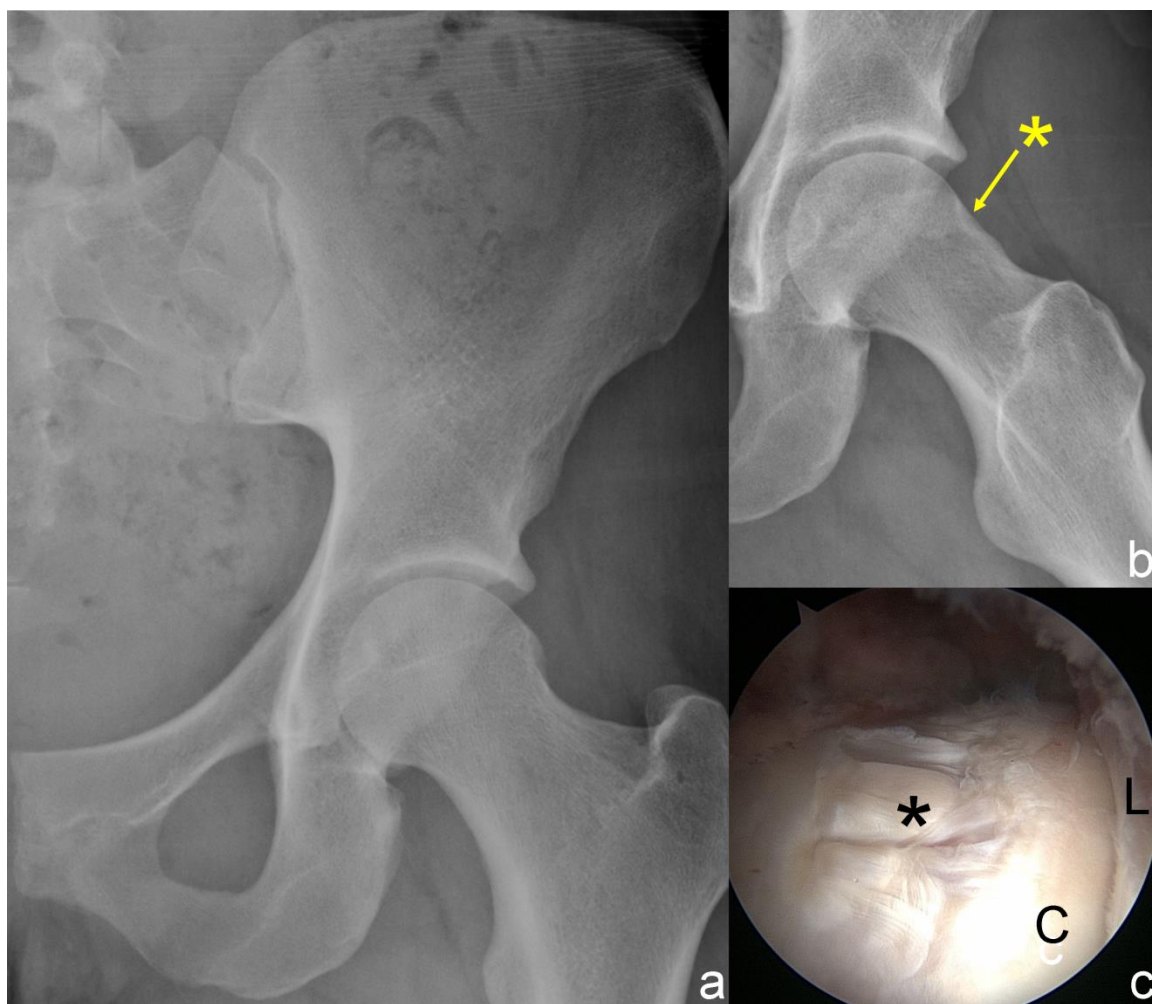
Radiographic and intraoperative imaging of the left hip of Patient 3. a) Anteroposterior radiograph showing acetabular overcoverage b) Frog-leg lateral radiograph showing pincer groove (*). c) Arthroscopic view through the anterolateral portal (70 degree scope) of mechanical wear at the location of the pincer groove on the anterolateral femoral neck. L= Labrum, C= Femoral Cartilage.
